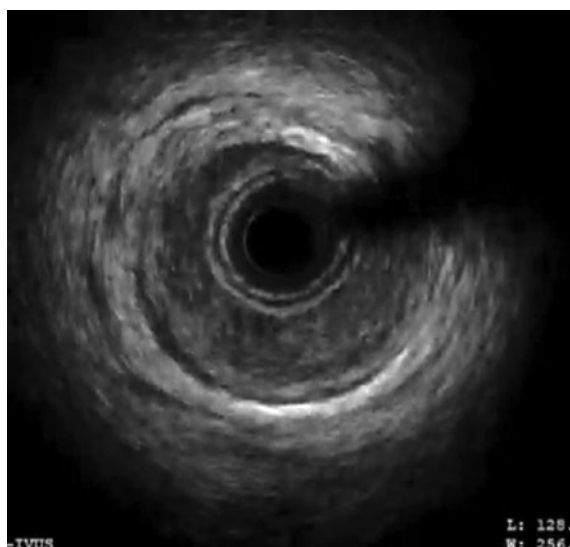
Intravascular ultrasound in the proximal anterior descending coronary artery. Image of a large intramural hematoma in the coronary artery compromising almost the entire vessel lumen.
